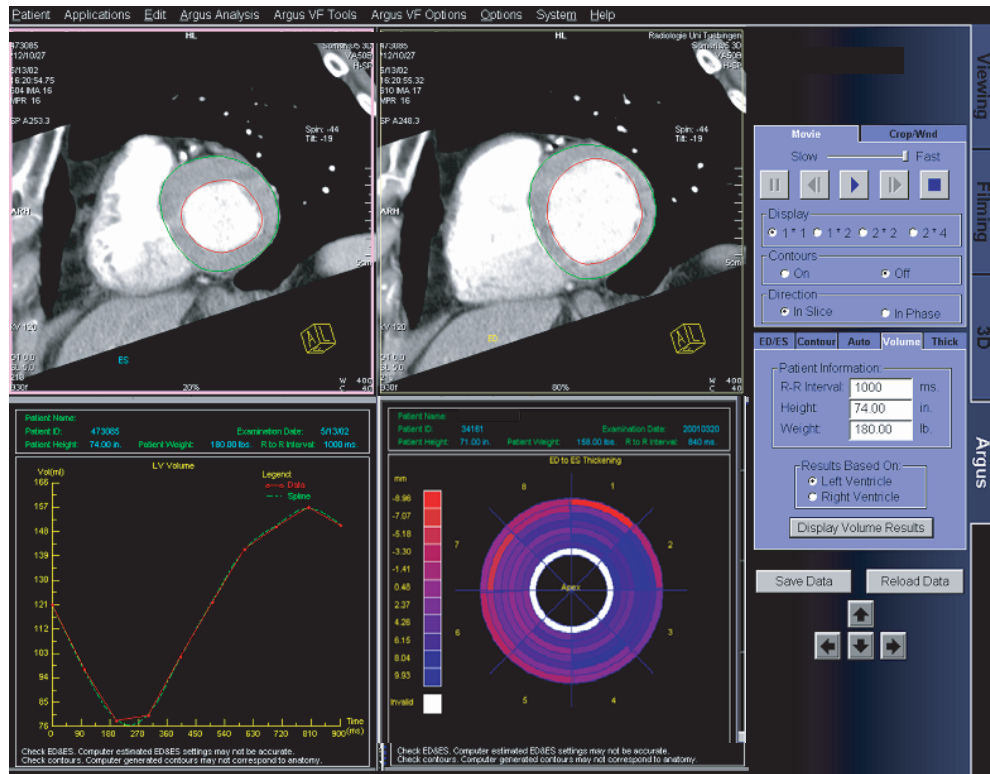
CT examination of a patient with an occlusion of the left descending coronary artery using a 16-slice CT scanner with 16×0.75 -mm collimation. Images for functional evaluation were reconstructed in 10 phases during the cardiac cycle, ranging from 0 to 90% of the RR-interval. The cardiac function evaluation software used in this example requires short-axis multi-planar reformations with 5- to 8-mm MPR thickness. It provides left ventricular volumes for all loaded phases, including end-systolic (*upper left*) and end-diastolic (*upper right*) volumes for determining ejection fraction (*lower left*). A “bullseye plot” for display of regional wall motion can also be generated (*lower right*). (Case courtesy of Tübingen University, Germany)
